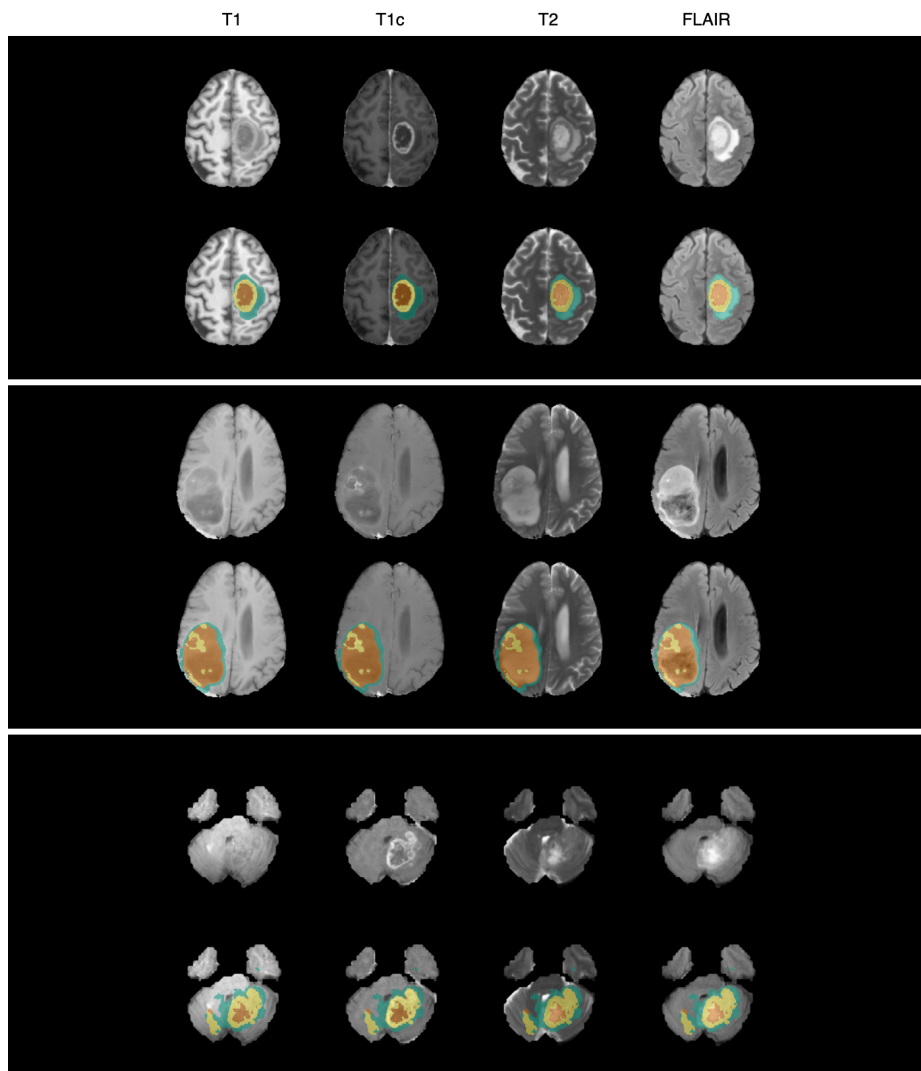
Three segmentation examples with varying expert assessment. T1, T1c, T2, and FLAIR images are displayed from left to right. The segmentations are overlaid in red for necrosis, yellow for enhancing tumor and green for edema. The 15 expert radiologists rated the top example *superior* with a mean of 5.73 stars, the middle example *mediocre* with a mean of 3.33 stars and the bottom example *inferior* with a mean of 1.93 stars.
